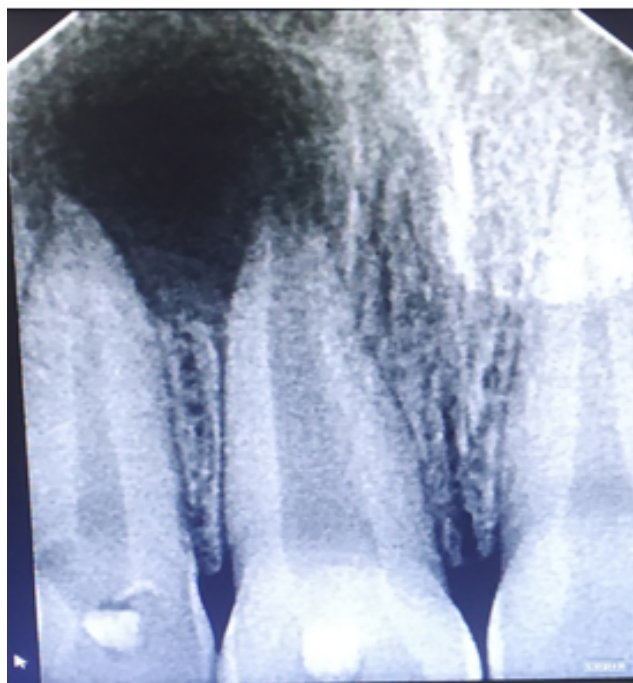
Radiograph after 1 month
